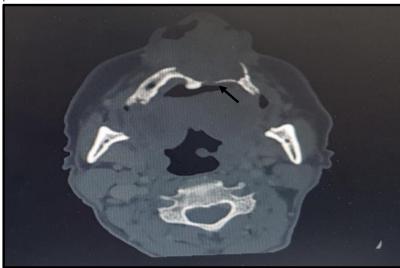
CT Paranasal sinus, axial view bone window, where arrow shows evidence of erosion along the floor of nose.
